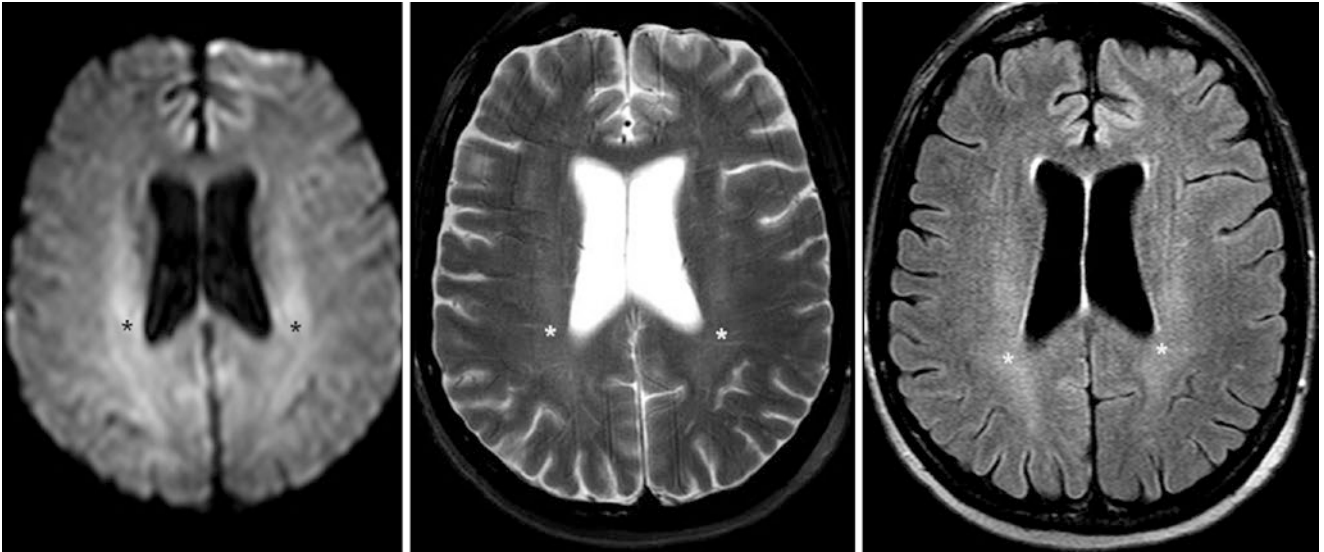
A 3 T MRI in a 60-year-old shows normal hyperintensity within the PVWM (*asterisk*) bilaterally on DWI (*left*), with mild corresponding hyperintensity on T2WI (*middle*) and on FLAIR (*right*). An ADC map (*not shown*) was normal
